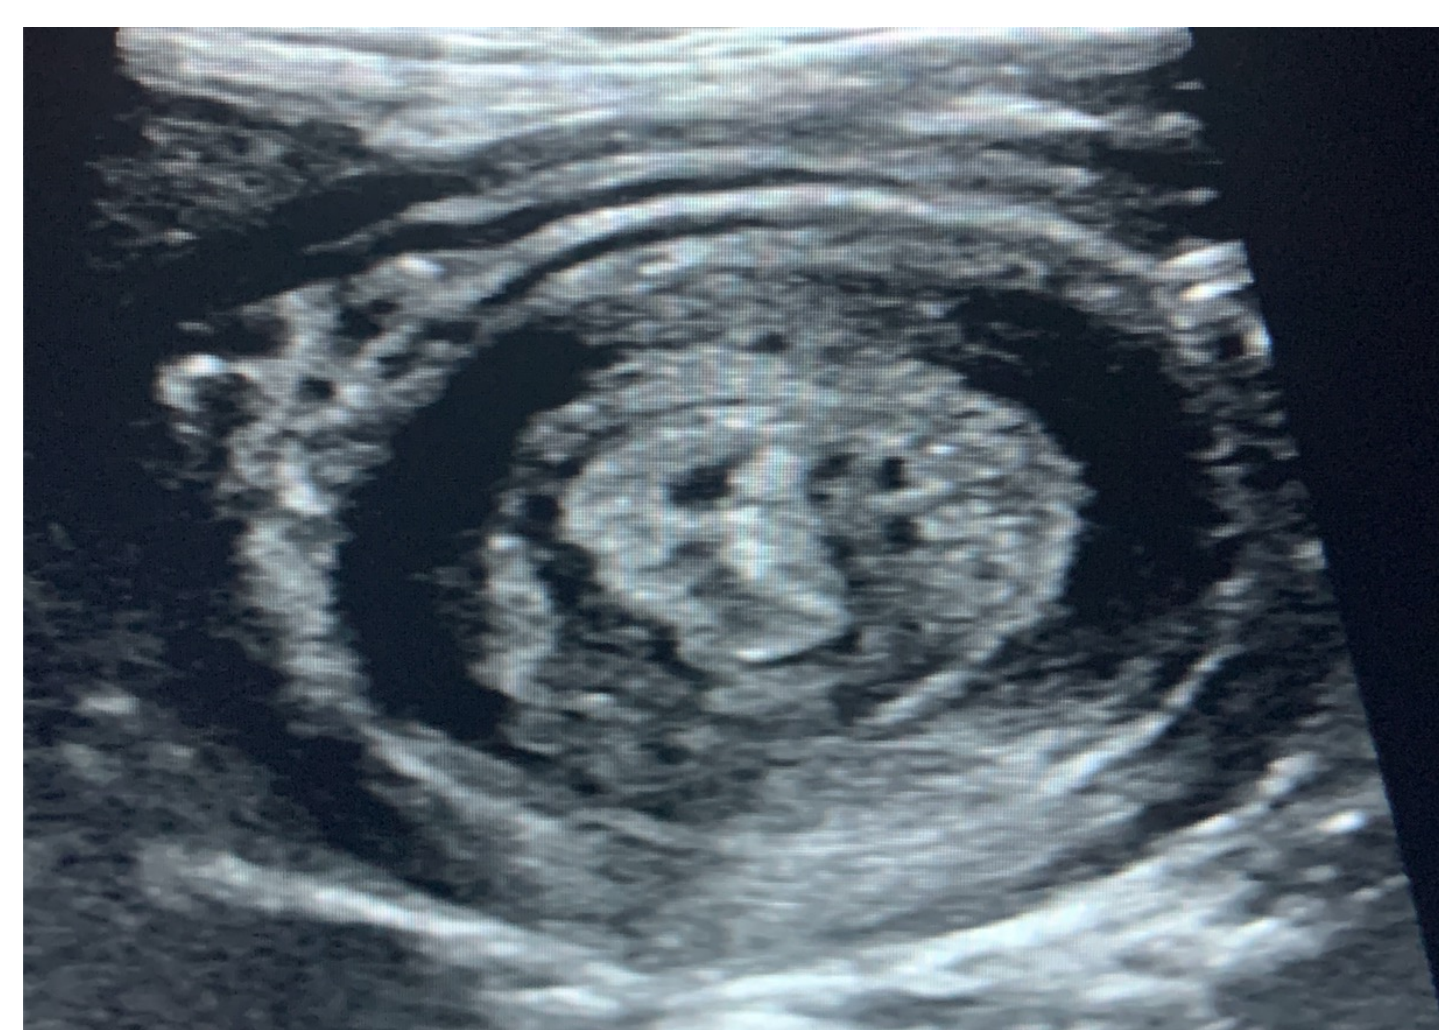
Abdominal ultrasound with Grayscale and color Doppler sonographic imaging reveals a mass in the distal stomach immediately adjacent to the balloon portion of the gastrostomy tube. Color Doppler evaluation shows evidence of blood flow in the walls of the intussusceptum and intussusciptens.
